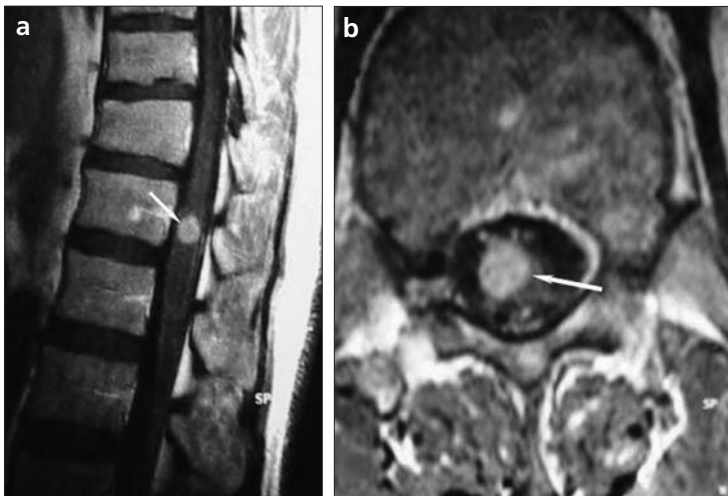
a, b. Contrast-enhanced sagittal (a) and axial (b) T1-weighted MR images show intense enhancement of the lesion (arrow).
